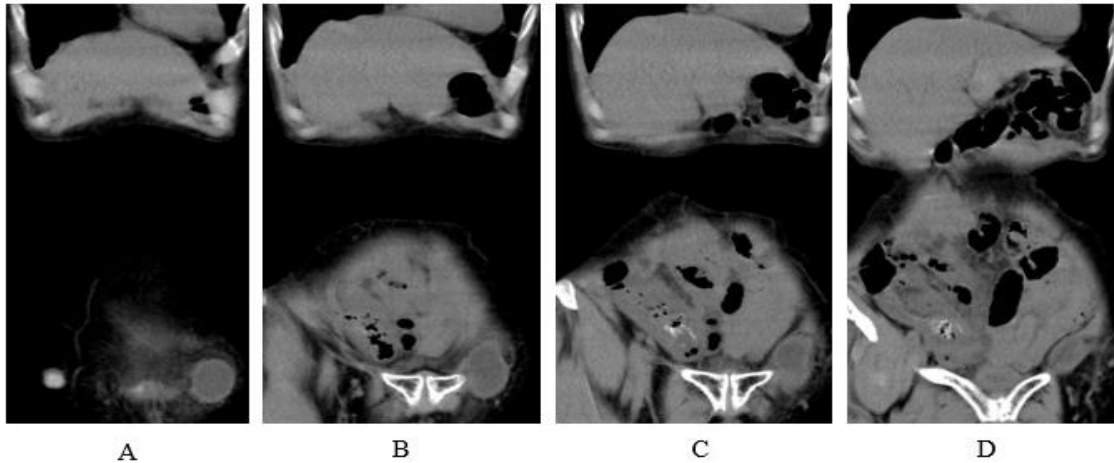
A cystic lesion on left inguinal hernia is depicted on coronal pelvic CT (A-D). It enters from outside of inguinal bands (D) and stays on inguinal canal (A-C) . Note a calcified lesion is found on right inguinal band (A).
